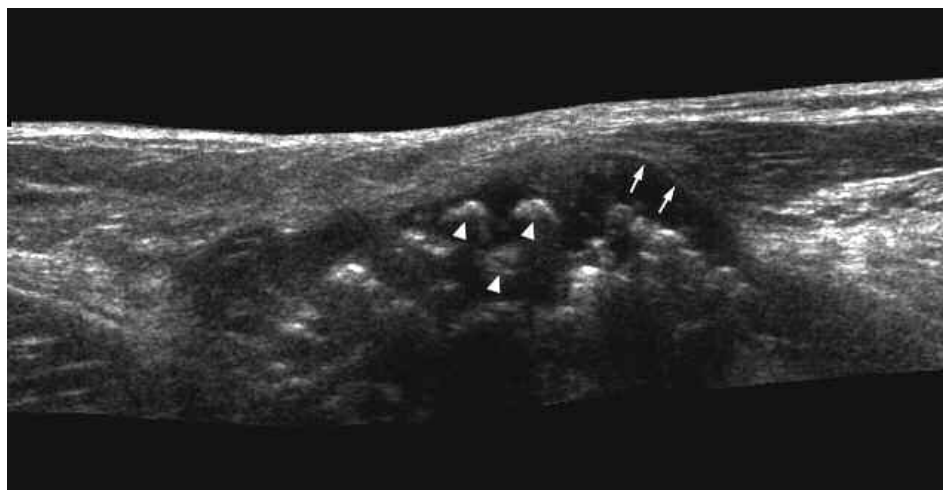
Ultrasound image showing hyperechogenic loose bodies in a Baker's cyst. Arrows: outer contour of Baker's cyst; arrowheads: loose bodies.
